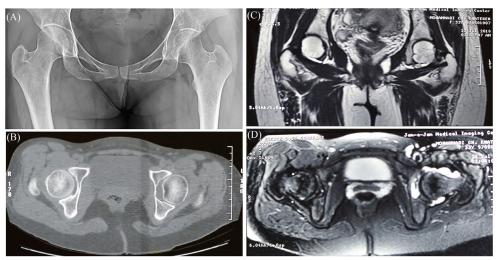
(A) Pre-operative anteroposterior radiograph of the hip showing an increased distance was noticed between the femoral head and the lateral aspect of teardrop; (B) CT scan of the hip showing an enlargement of fovea capitis; (C) Coronal T1-weighted MRI of the hip showing an intermediate signal density in the enlarged fovea capitis; (D) Axial T2-weighted MRI of the hip showing a high-intensity signal around the head and neck of the femur.
